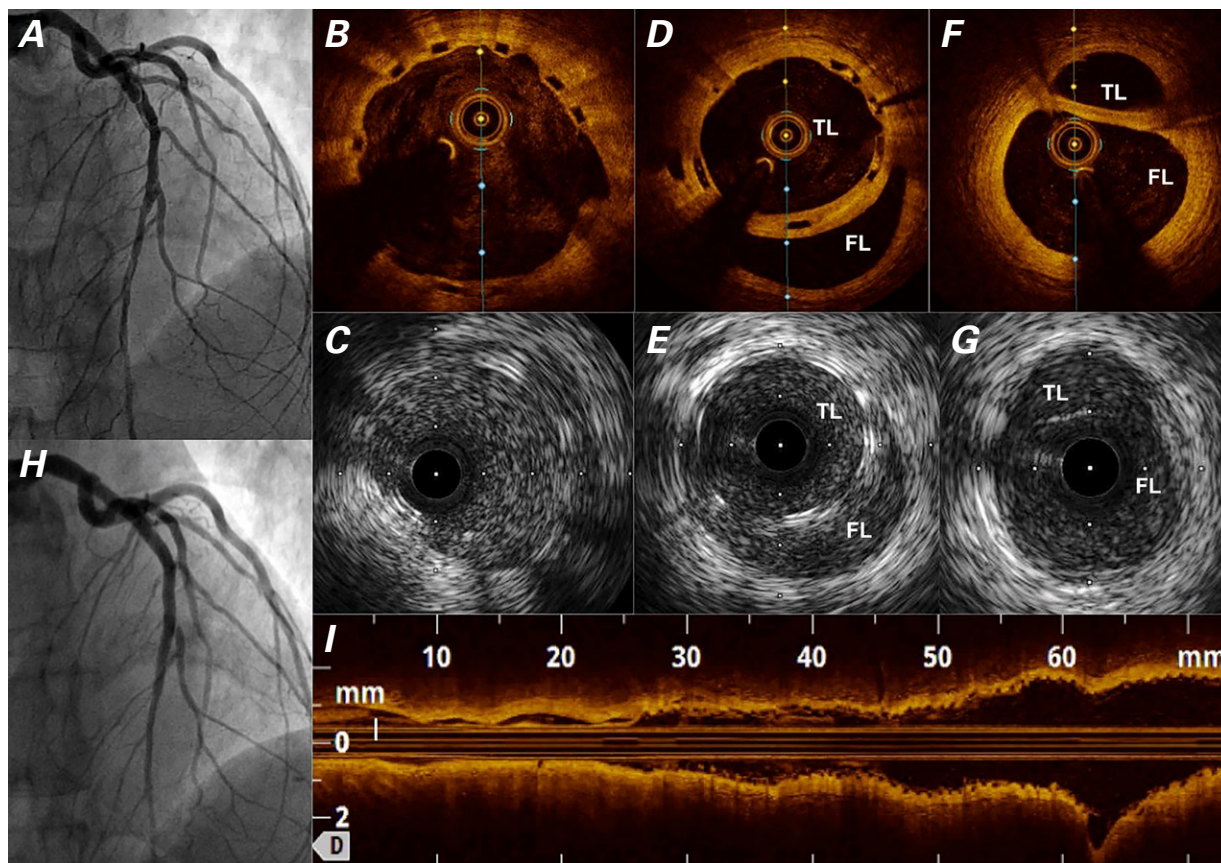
Patient 4. A) Angiogram during first bioresorbable scaffold (BRS) implantation shows remaining dissection of the left anterior descending coronary artery (LAD) distally. At one year, corresponding B) optical coherence tomogram (OCT) (axial view) and C) intravascular ultrasonogram (IVUS) confirm a widely patent BRS implanted in the true lumen (TL) of the proximal LAD. D), E) Corresponding images show the previous BRS implanted in the TL and, immediately distal to that, a double lumen with a large false lumen (FL). F), G) Corresponding images show the guidewire in the FL, and a smaller TL. H) Angiogram shows the result after BRS implantation. I) Optical coherence tomogram (long view) after implantation of 3 BRSs reveals good apposition with a small dissection in the very distal LAD.
